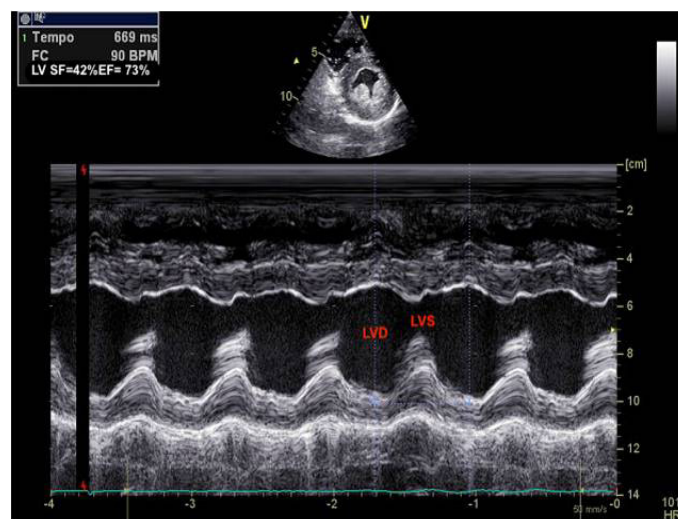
Transthoracic echocardiogram at the transverse plane of ventricles (short ventricular axis) showing maximum and minimum diameters of the Left Ventricle (LV) and calculation of the Ejection Fraction (EF) and Shortening Fraction (SF) of the LV in a healthy individual. The equations used for calculation by the Teichholz method are $EF (\%) = \frac{\text{maximum diastolic diameter of } LV^3 - \text{maximum systolic diameter of } LV^3}{\text{maximum diastolic diameter of } LV^3} \times 100$ (normal EF: >55%). $SF = \frac{\text{maximum diastolic diameter of } LV - \text{maximum systolic diameter of } LV}{\text{maximum diastolic diameter of } LV} \times 100$ (normal SF: >28%).
